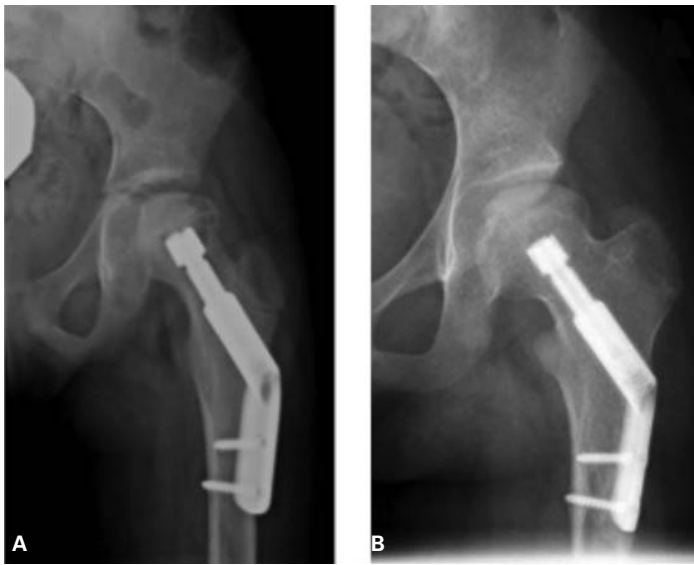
(A) Postoperative AP image of left hip in a 9-year-old female after core decompression, iliac crest bone grafting, and stabilization with a compression hip screw for AVN, and (B) AP Xray at 5-year follow-up visit showing no progression of AVN.
